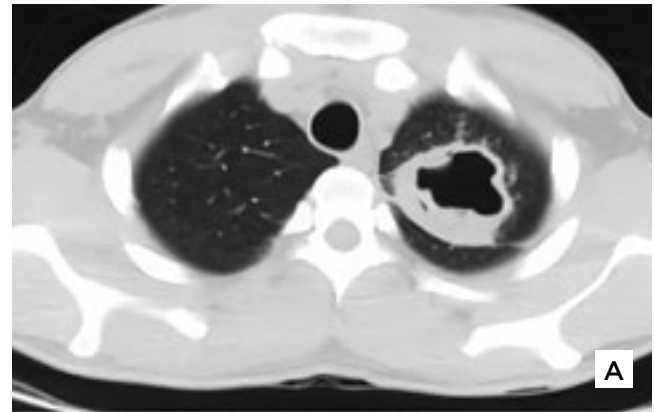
CT scan of the lungs. A, Axial Lung CT demonstrates a thick wall cavity in the left upper lobe containing a fluid level. B, Sagittal reformatted projection demonstrating pulmonary cavity contact with the posterior chest wall at the second intercostal space (white arrow)
